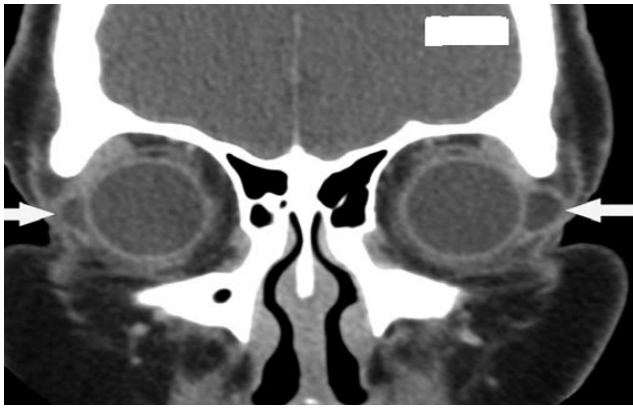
CT image showing bilateral dacryops
